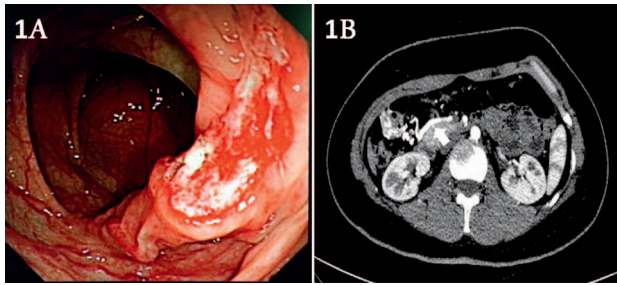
(A) Appearance of a solitary ulcer located in hepatic flexure of colon. (B) The abdominal CT scan was performed, which showed marked enhancement of the superior mesenteric vein in the arterial phase, the fistula of the neck between the superior mesenteric artery, and the superior mesenteric vein.
